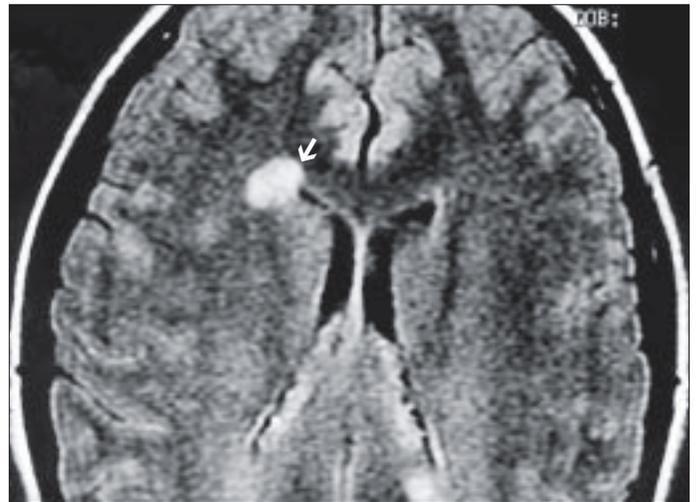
Axial FLAIR MR image shows a hyperintense focus (arrow) in the periventricular white matter of the right frontal lobe.
